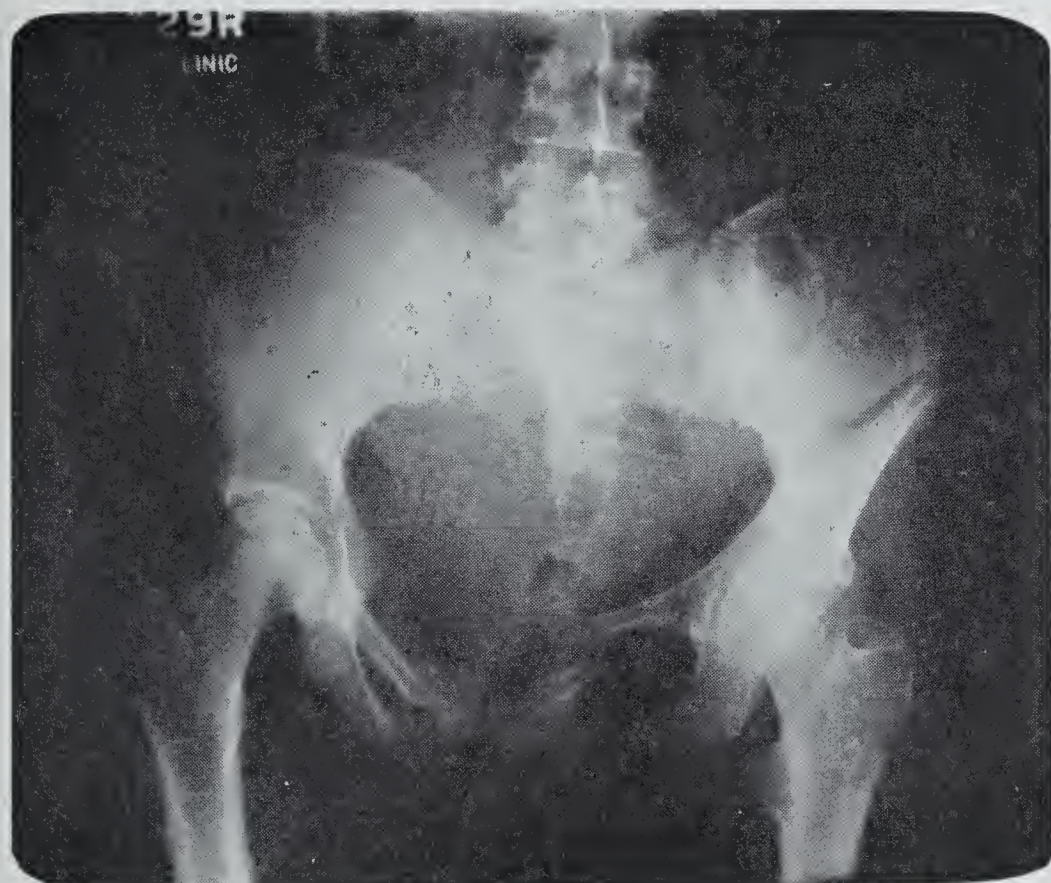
X-ray of the pelvis reveals fractures of both pubic rami and the left ilium. The left ramus was displaced upward, severing the left lateral wall of the bladder for about three inches.
